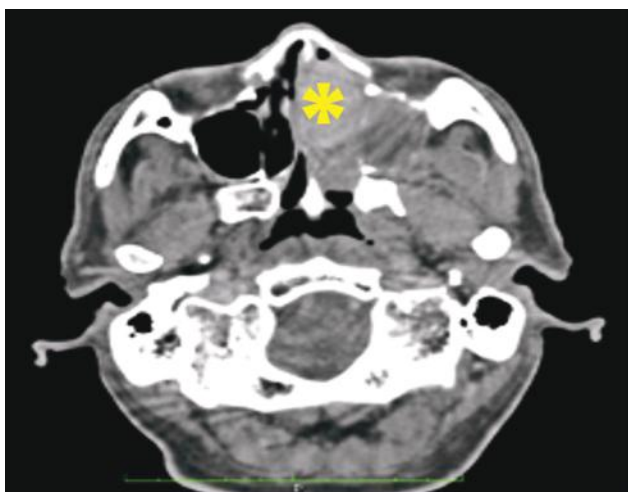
Paranasal sinus CT scan findings showing a solid mass in the left nasal cavity (*), deviating the nasal septum and obstructing the left ostiomeatal unit.
